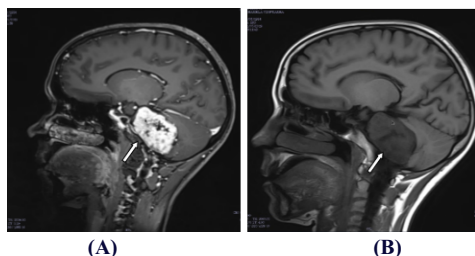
(A & B) :Sagittal T2-weighted magnetic resonance imaging showing a large lesion involving the right side of the cerebellopontine angle and normal ventricular size.
